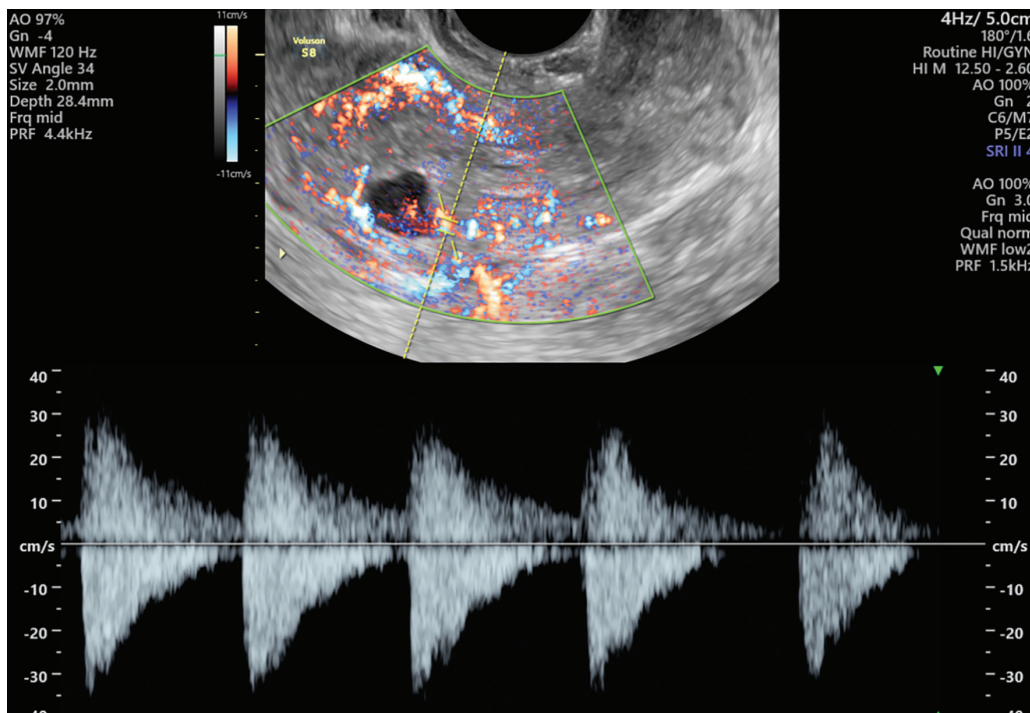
Spectral Doppler demonstrating high velocity arterial flow into the cavity. Pulse repetition frequency 1.5 kHz. Peak systolic velocity 30 cm/s.
